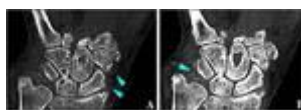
CBCT-images with the presence of the tightened collateral ligaments of the...
